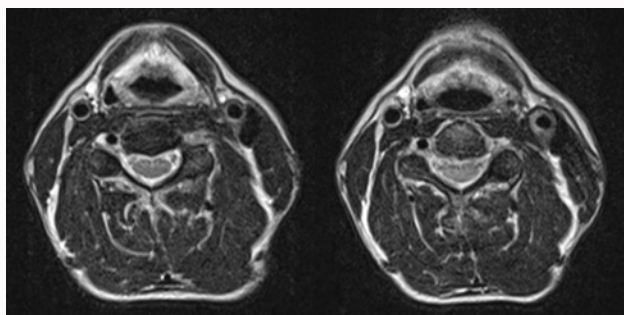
Three months follow up MRI showing similar appearances of distal left common carotid artery and carotid bifurcation.
